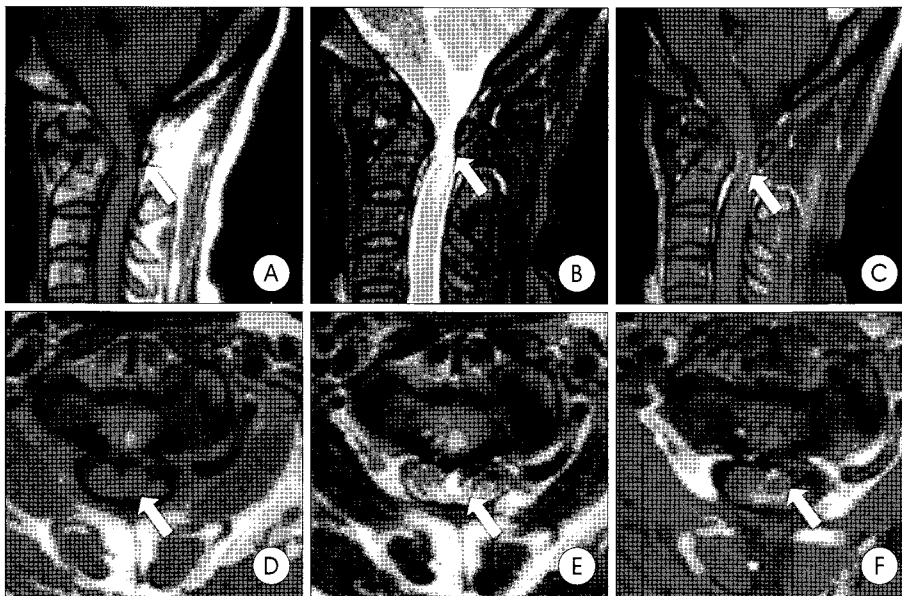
A : Sagittal T1-weighted image indicating a round cystic mass (arrow) with low signal intensity, located at the transverse atlantal ligament. B : Sagittal T2-weighted image indicating a round cystic mass with high signal intensity. C : Contrast enhanced T1-weighted image indicating a peripheral rim enhanced cystic mass. D-F : Corresponding axial image revealing the same round cyst, compressing the spinal cord, which located at the transverse atlantal ligament.
